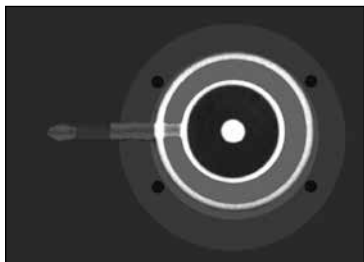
X-ray of the VG Access Port with "free floating" radiopaque dot in center
